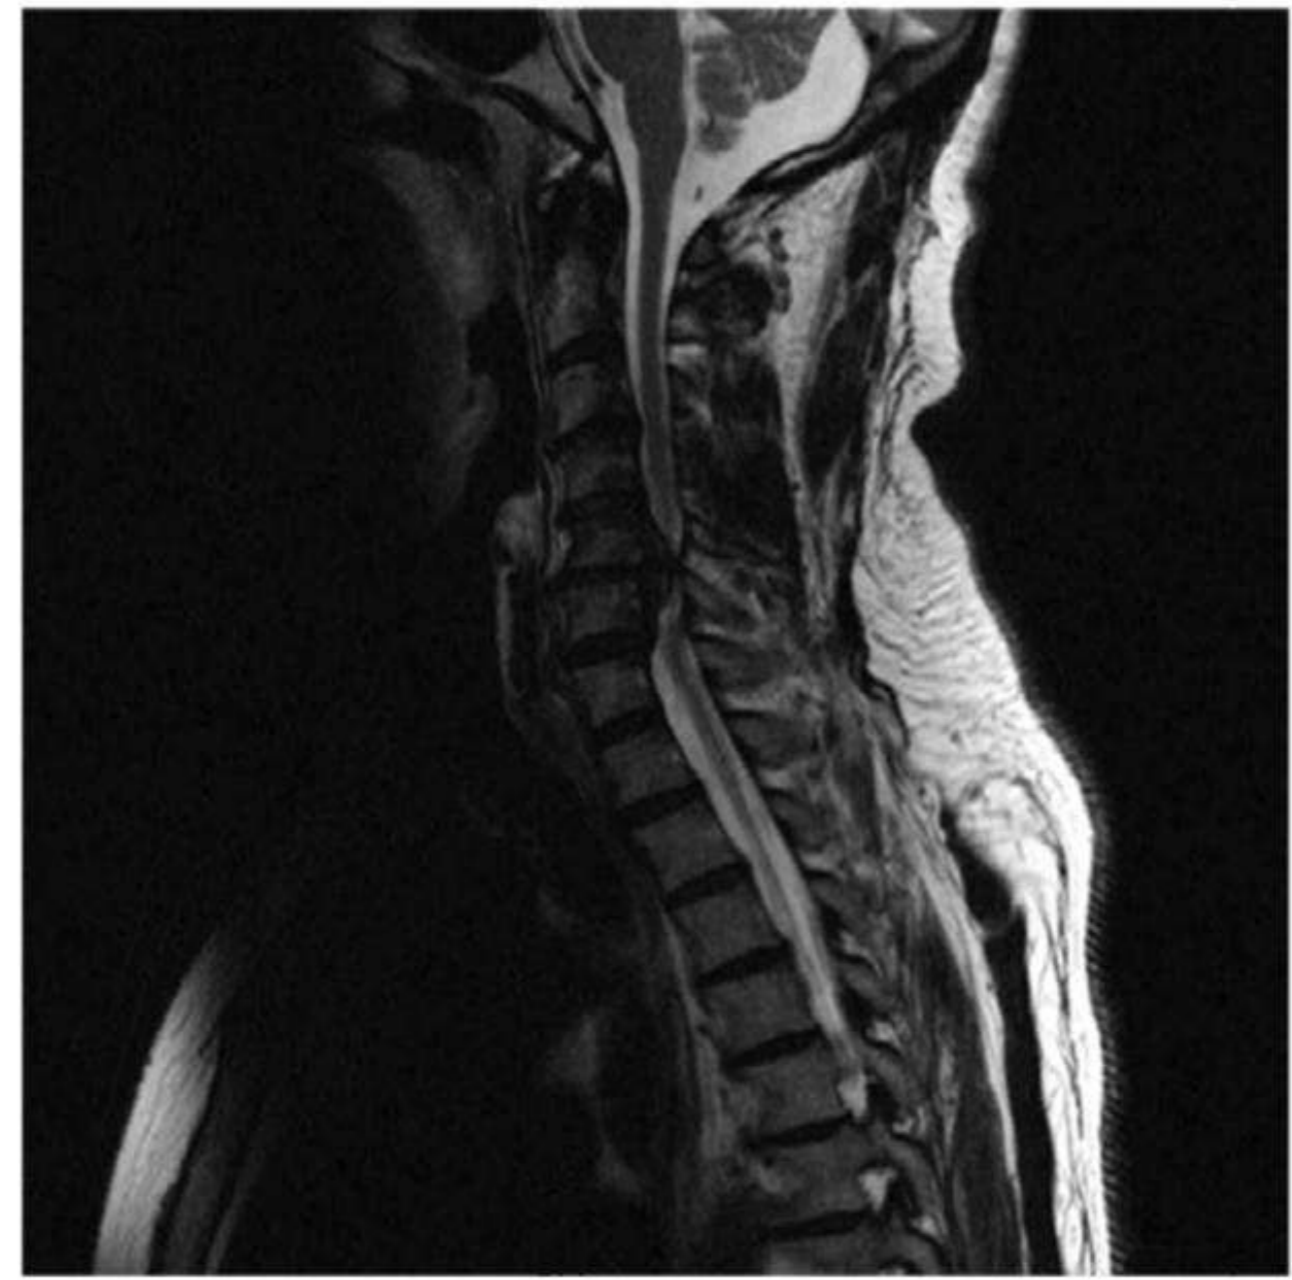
T2-weighted sagittal MRI image demonstrating cervical stenosis.
